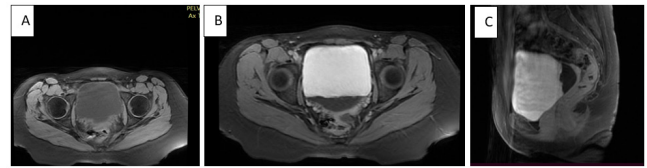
Magnetic resonance of pelvis. A) axial T1 (FS)-weighted images, B) axial and C) sagittal contrast-enhanced T1 (FS) - weighted images contrast-enhanced T1-weighted images.
